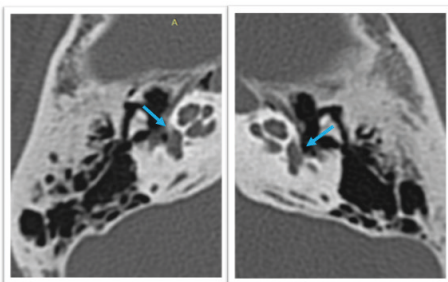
Axial CT images of the temporal bones showing otosclerosis classified as grade 2A in a 51-year-old male patient. Note a reduction in usual bone density and narrowing of the basal turn in both ears (blue arrows).
